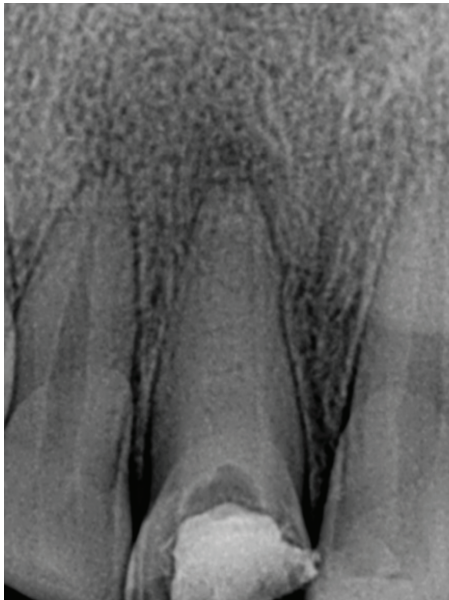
Intra-oral radiograph after placement of calcium hydroxide. (Far left)
